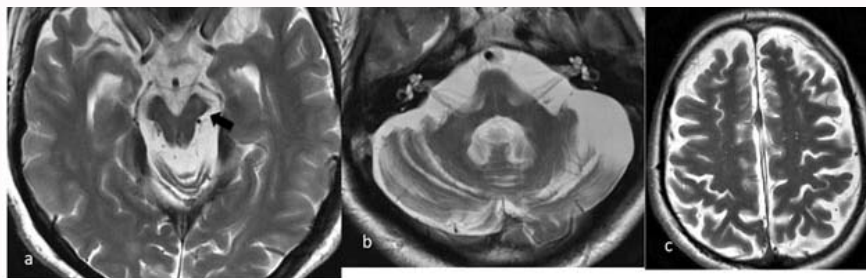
MRI of the brain, acquired 3 years later; axial T2-weighted image shows (a) signal abnormality and atrophy of the cerebral peduncles (arrow), (b) cerebellar atrophy and (c) moderate cerebral volume loss with hypointense nodular thickening along the falx cerebri.
